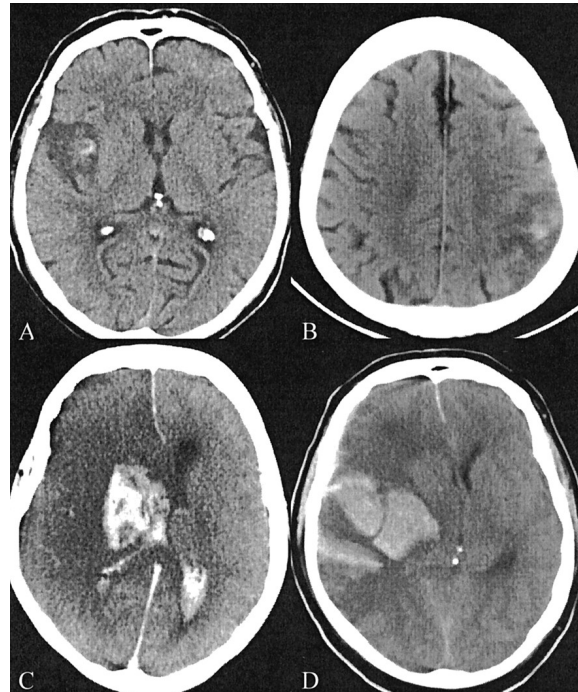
Example of ECASS definition for defining haemorrhagic transformation on CT (A) HI1, (B) H12, (C) PH1, (D) PH2
